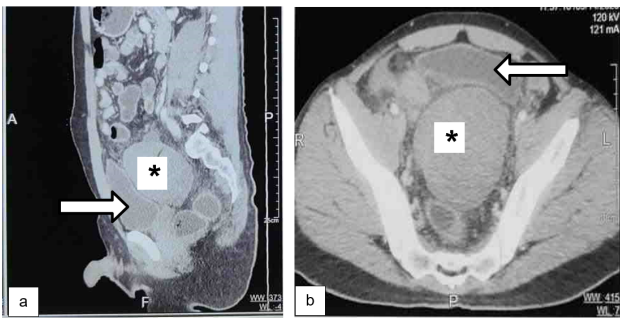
Coronal (a) and axial (b) section of plain CT abdomen showing well-defined lobulated solid soft tissue mass (asterisk) in the hypogastric region in the supra-vesical area (urinary bladder marked by white arrow)
